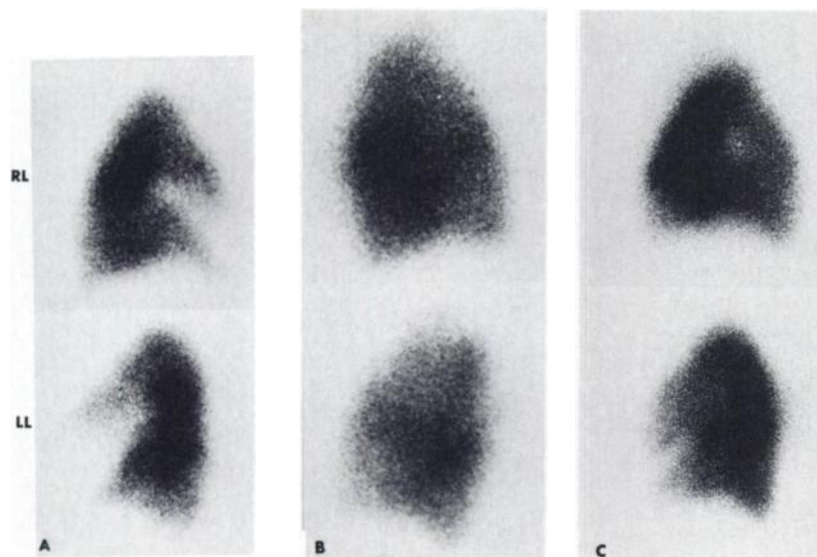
Right (RL) and left (LL) lateral views of perfusion lung scintigrams of Patient 1. For discussion see text. (A) May 22, 1975: perfusion is absent from middle lobe and anterior segment of lower lobe, right; from lingulae; and from anterior and posterior segments of lower lobe, left. (B) Jan. 28, 1977: no perfusion defect present on lateral views. (C) March 13, 1979: perfusion is absent from anterior segment of lower lobe, right, and from inferior lingula and anterior and posterior segments of lower lobe, left.
